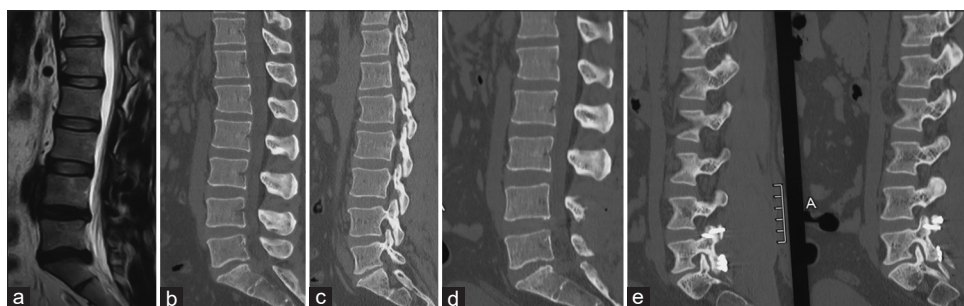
Images of a 41-year-old male patient. (a) T2-weighted MRI shows evidence of lumbar canal stenosis. (b) CT scan showing canal stenosis. (c) Sagittal cut of CT scan showing the facets. (d) Postoperative CT scan. (e) Postoperative sagittal CT scan showing the double insurance transfacet screws at L4-L5 level and triple insurance screws at L5-S1 level. MRI - Magnetic resonance imaging; CT - Computed tomography
